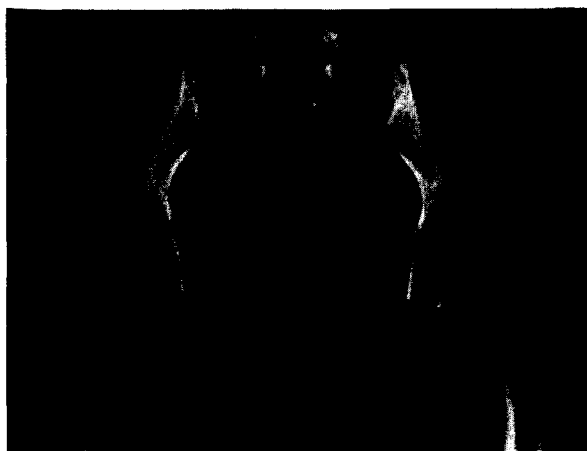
Initial pelvic radiograph (taken 3 weeks after the onset of symptoms) showing normal pubic symphysis.
